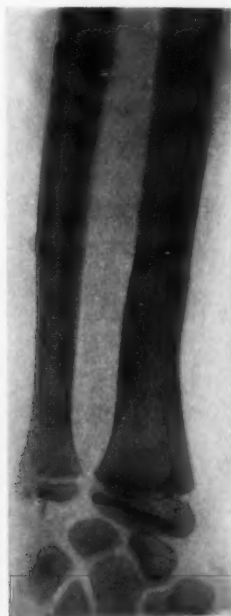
Same bones as Fig. 1. X-ray taken one year later, showing good repair of bones.
